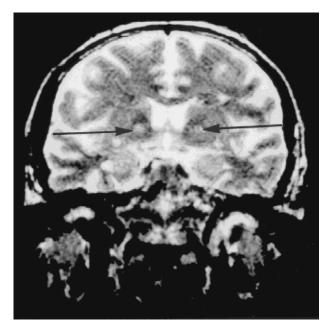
Coronal T2-weighted MRI showing bilateral hypersignal lesion in the globus pallidus.
